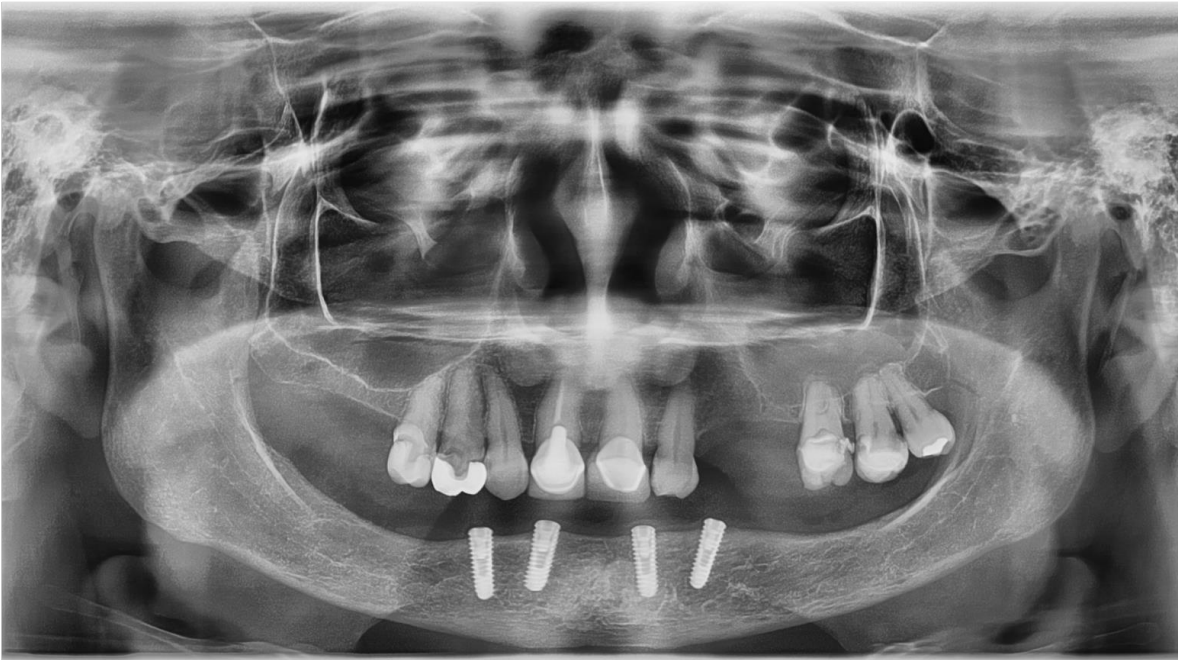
Panoramic radiograph showing the osseointegration of the four implants, with no signs of peri-implant growth, no bone loss or changes in the bone trabeculate.
